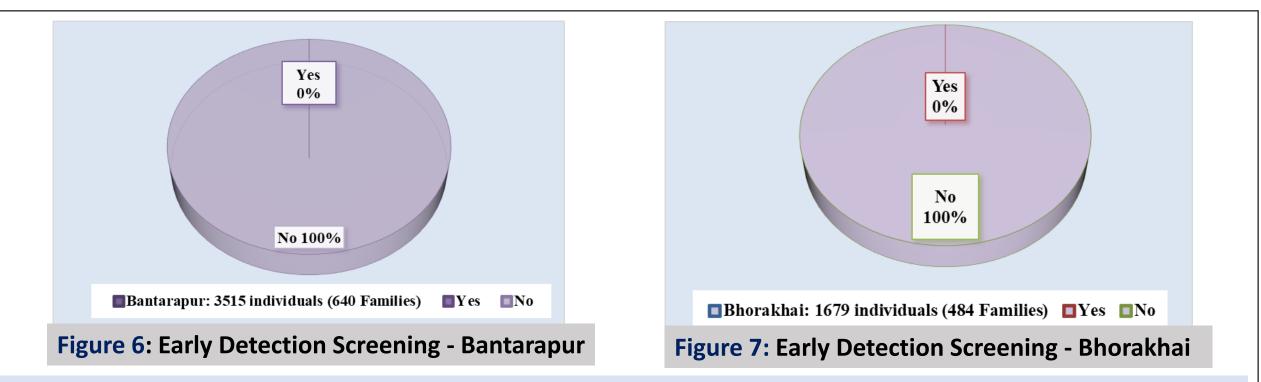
& Figure 7: The concept of early detection screening - Breast Self-Exam, Clinical Breast Exam, Mammogram or Ultrasound, Pap & HPV tests is zero. Women & men visit the doctors only when the situation goes beyond control leading to late detection.
